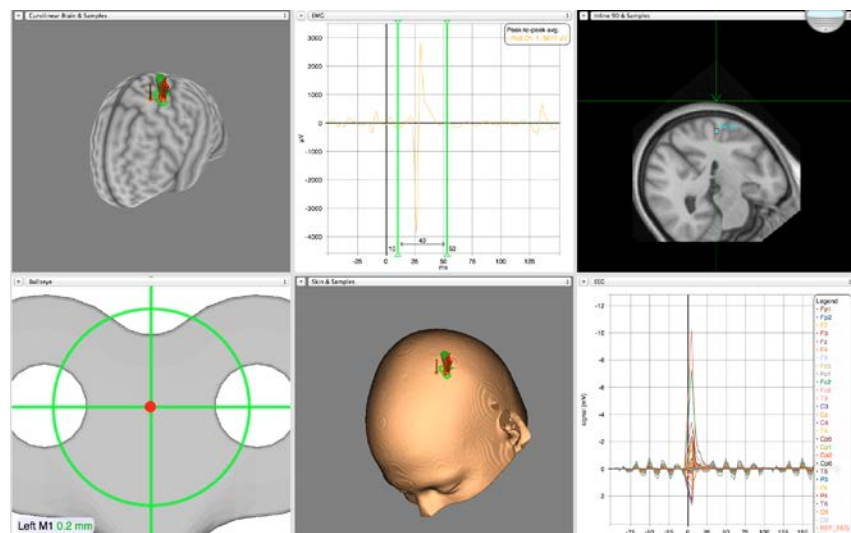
Real-time integration of EEG, TMS, EMG and MRI template information using BrainSight system.
